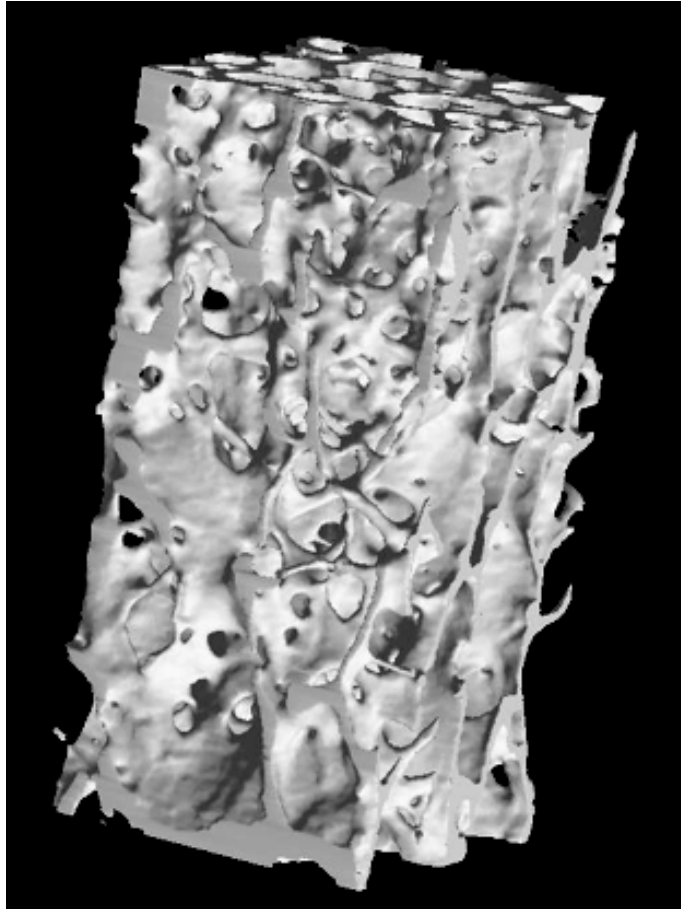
Trabecular bone. 3D  $\mu$ -CT image of human trabecular bone (extracted from femoral head). Image provided courtesy of D.M.L. Cooper.
